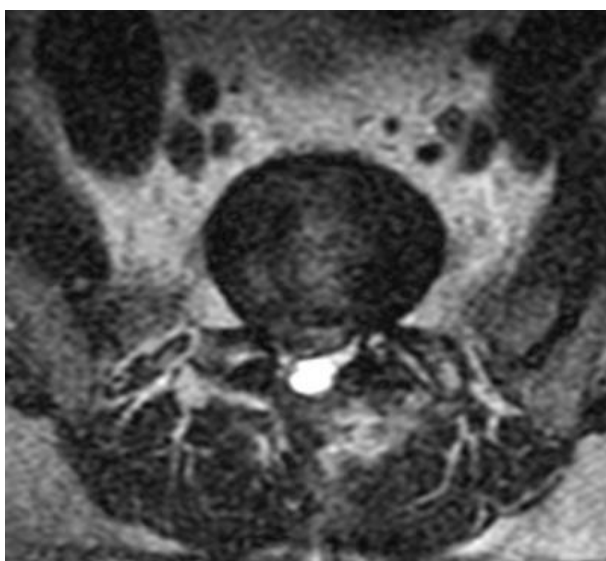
MRI scan showing disc herniation with lumbar canal stenosis
